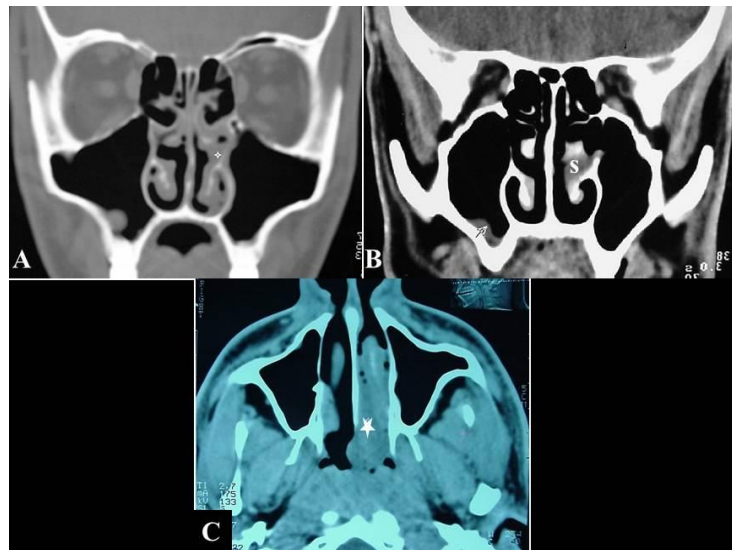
(A, B) CT scan with coronal bone window and soft tissue cuts showing a soft tissue density mass appeared attached to the uncinete process (white cross in A), and seen in the middle meatus in the region of the left maxillary sinus ostium (s in B) with clear paranasal sinuses on that side. Localized mucosal thickening of the right maxillary sinus was seen (white arrow in B). (C) CT scan with axial soft tissue cut shows that this soft tissue density mass fills most of the posterior part of the left nasal fossa (white asterisk) and projects through the choana into the nasopharynx, with a clear maxillary sinus on that side.
